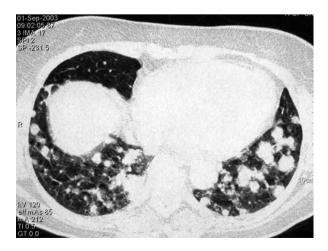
HRCT; multiple, various sized nodules in both lungs predominantly in the lower lung zones
